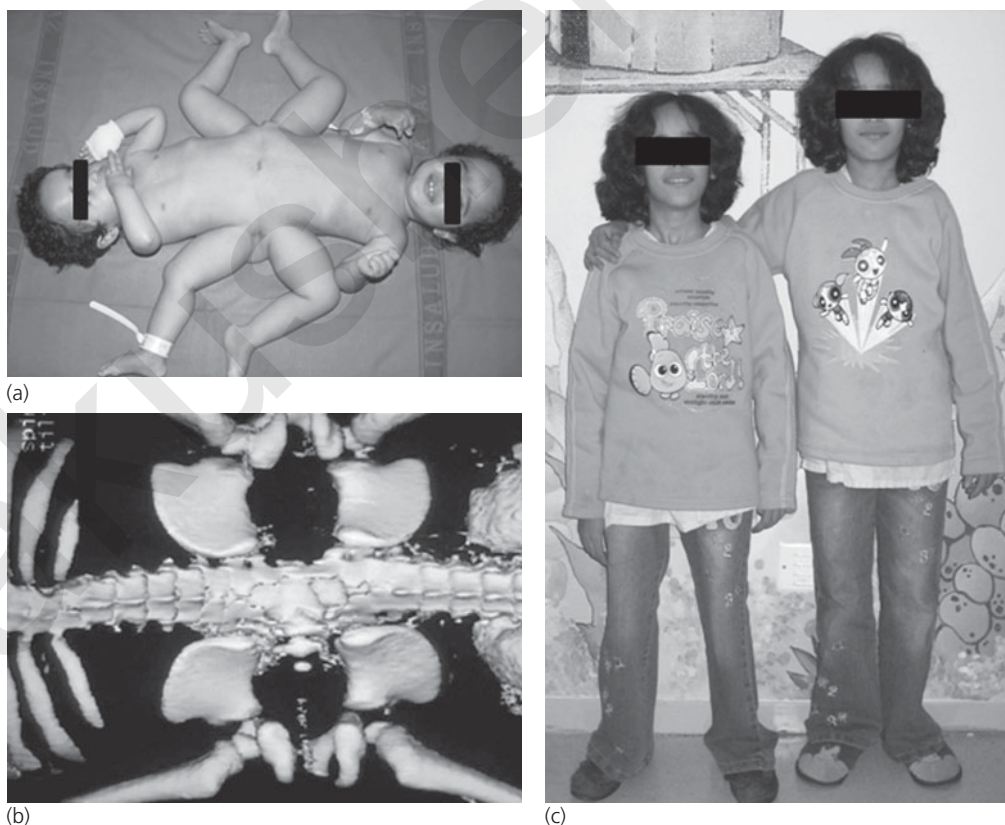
(a) Ischiopagus tetrapus (four legs) twins. (b) The spines and the spinal cords were joined at the caudal end as shown by helicoidal computed tomography reconstruction. During separation, the spines were divided, the meningeal sacs were reconstructed, a quadruple iliac osteotomy was performed for joining both pubic bones in each twin, the urogenital system was reconstructed, and colostomies were fashioned. (c) Patients at the age of 12 years. They deambulate normally and enjoy relatively normal lives with permanent colostomies and intermittent bladder catheterization.
